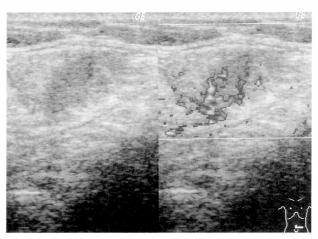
Color Doppler ultrasonography showing a well-defined and hypervascular mass in the rectus abdominis measured 22×20 mm.
